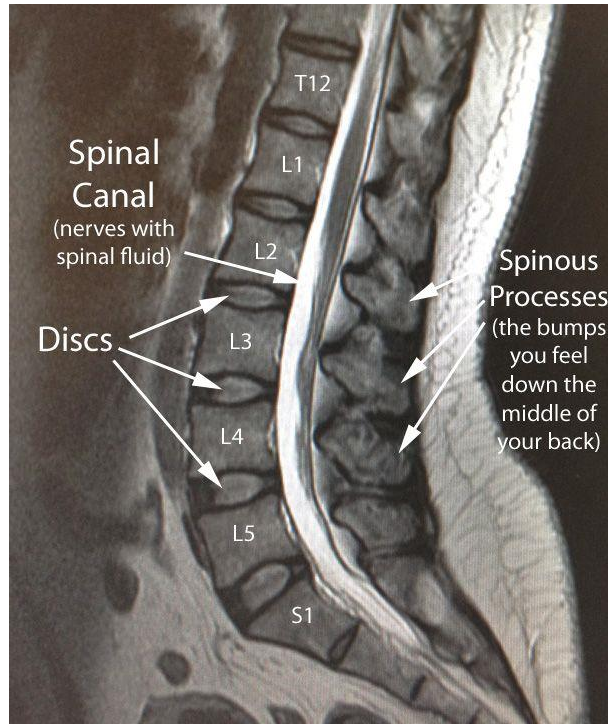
Show normal image of sagittal T2-weighted MRI scan of lumbar spine (Sibel, 2018)
